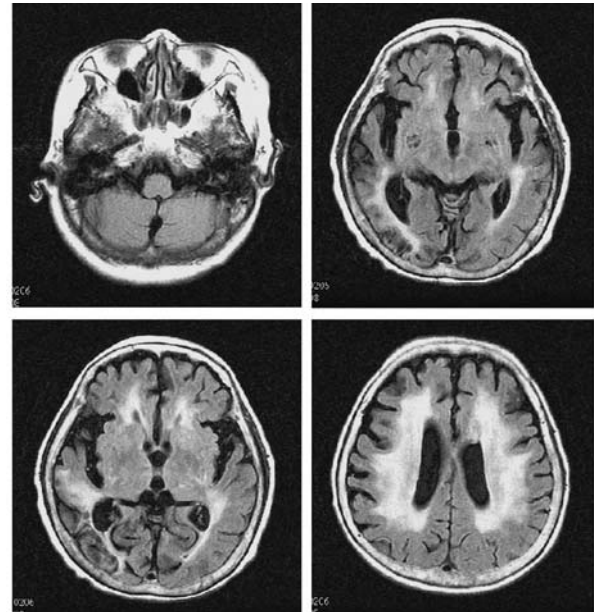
Follow-up FLAIR MRI 3 weeks later shows gradual disappearance of the lesions with high signal intensities on the previous examination.
